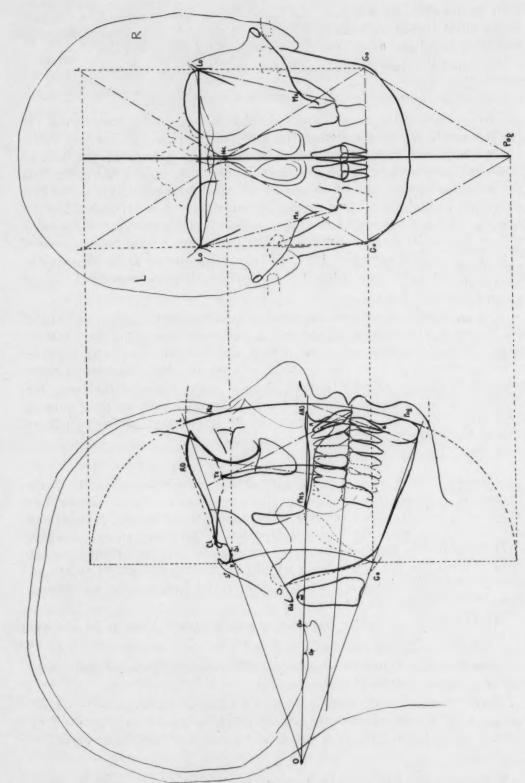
Three-dimensional analysis of the lateral and frontal cephalometric x-ray films.
